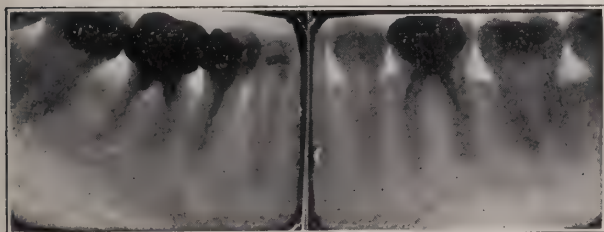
Pulpless teeth which do not show any X-ray evidences of structural changes which might indicate pathology.
